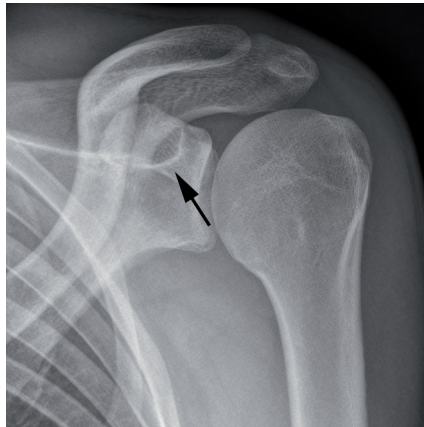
An asymptomatic lesion in the scapula of a 20-year old patient that was discovered accidentally on radiographic imaging.
